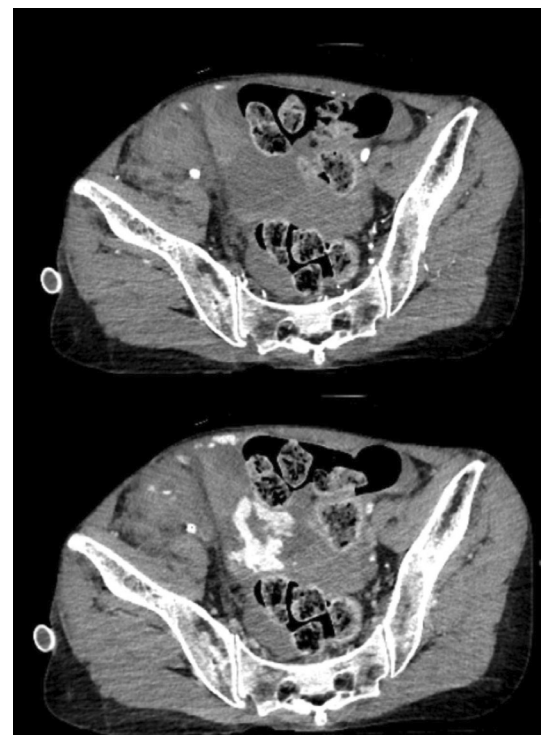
Enhanced computed tomography showing extravasation of the contrast medium in the pelvis. (Top: arterial phase, Bottom:parenchymal phase).
